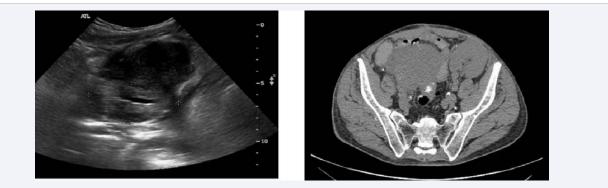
Radiographs A- Heterogeneous appearance of pancreas and adjacent tissue on US & B- An 8.0 x 7.3 cm area of soft tissue attenuation in the right hemipelvis, in the region of the pancreatic transplant (CT with contrast); this area corresponds to the globular necrotic pancreas head on subsequent pancreatectomy (with final diagnosis of PTLD).
